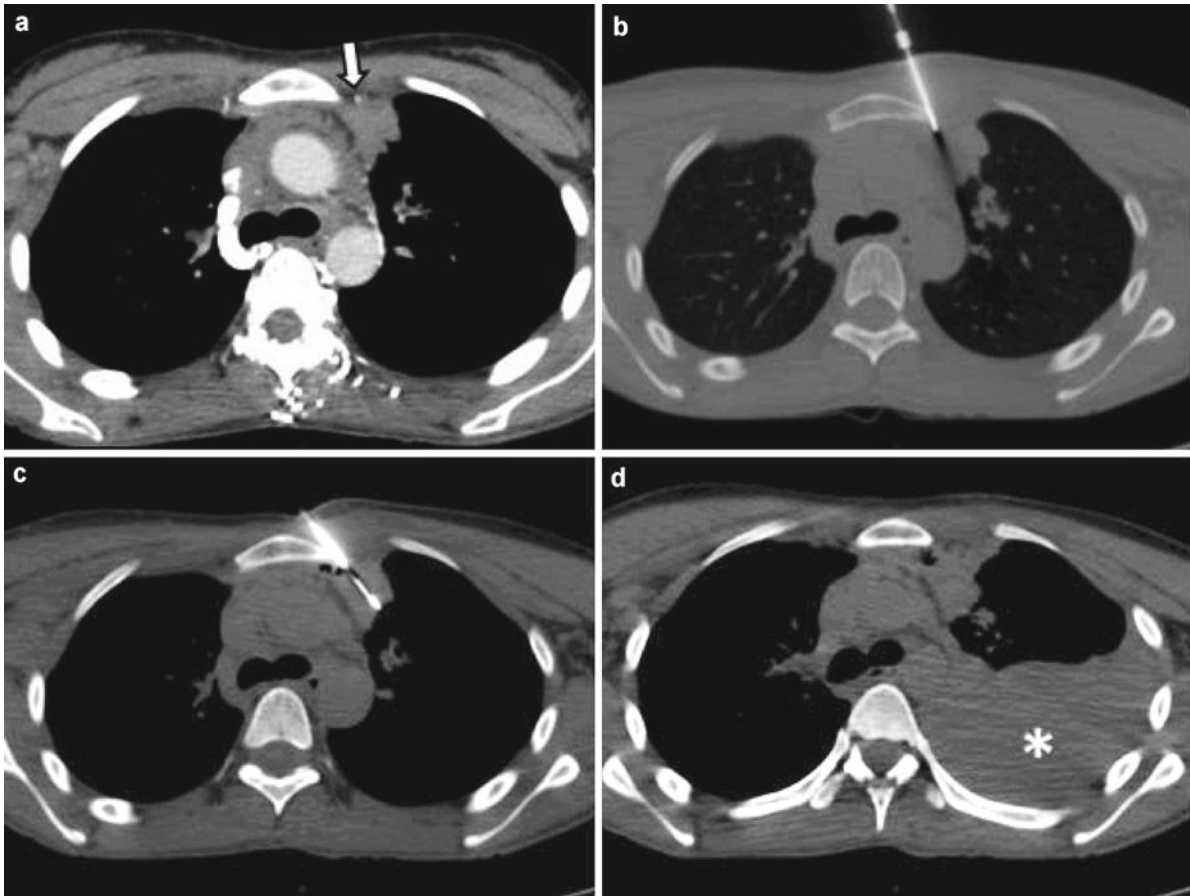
CT-guided lung biopsy in an 18-year-old patient with suspected relapsing Hodgkin's disease. Care was taken to stay close to the manubrium (image b) to avoid the internal thoracic
